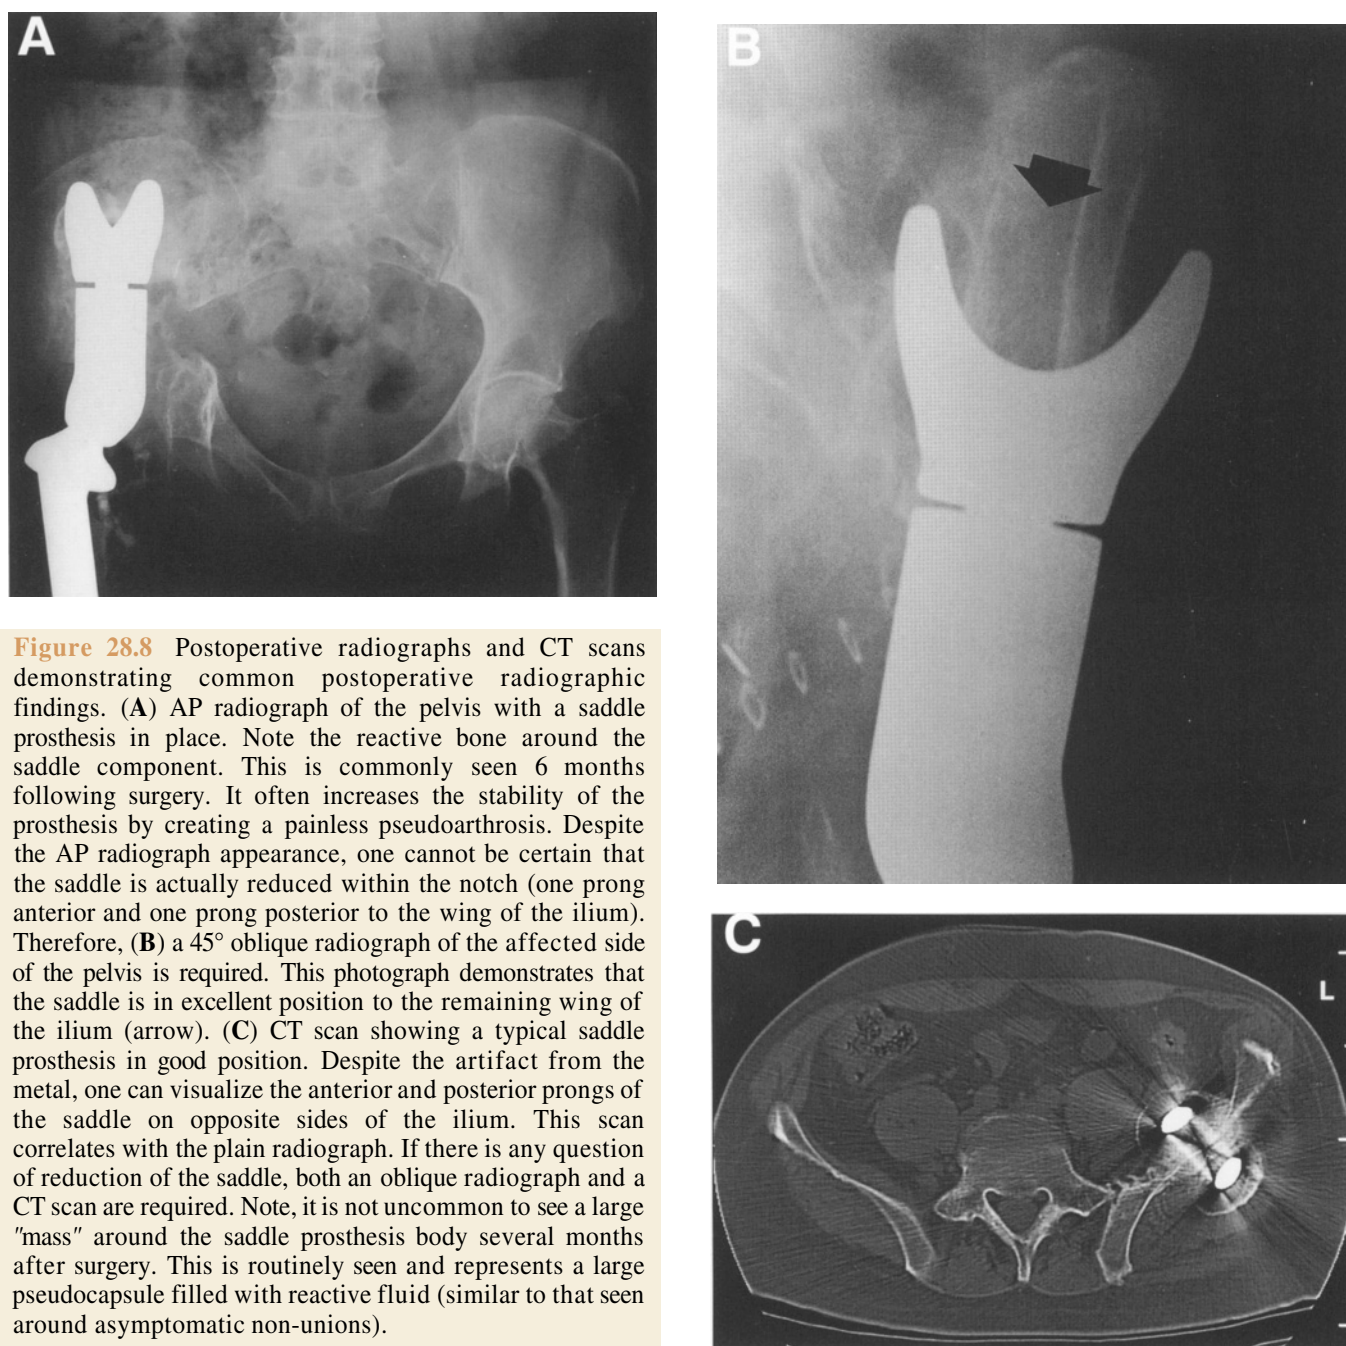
Postoperative radiographs and CT scans demonstrating common postoperative radiographic findings. (A) AP radiograph of the pelvis with a saddle prosthesis in place. Note the reactive bone around the saddle component. This is commonly seen 6 months following surgery. It often increases the stability of the prosthesis by creating a painless pseudoarthrosis. Despite the AP radiograph appearance, one cannot be certain that the saddle is actually reduced within the notch (one prong anterior and one prong posterior to the wing of the ilium). Therefore, (B) a 45° oblique radiograph of the affected side of the pelvis is required. This photograph demonstrates that the saddle is in excellent position to the remaining wing of the ilium (arrow). (C) CT scan showing a typical saddle prosthesis in good position. Despite the artifact from the metal, one can visualize the anterior and posterior prongs of the saddle on opposite sides of the ilium. This scan correlates with the plain radiograph. If there is any question of reduction of the saddle, both an oblique radiograph and a CT scan are required. Note, it is not uncommon to see a large "mass" around the saddle prosthesis body several months after surgery. This is routinely seen and represents a large pseudocapsule filled with reactive fluid (similar to that seen around asymptomatic non-unions).
